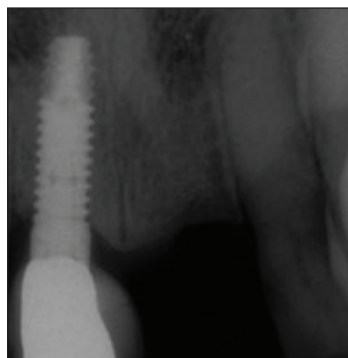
A 4-month postop radiograph demonstrates a lack of lamina dura from the extraction site and most of the graft is incorporated into the area.
